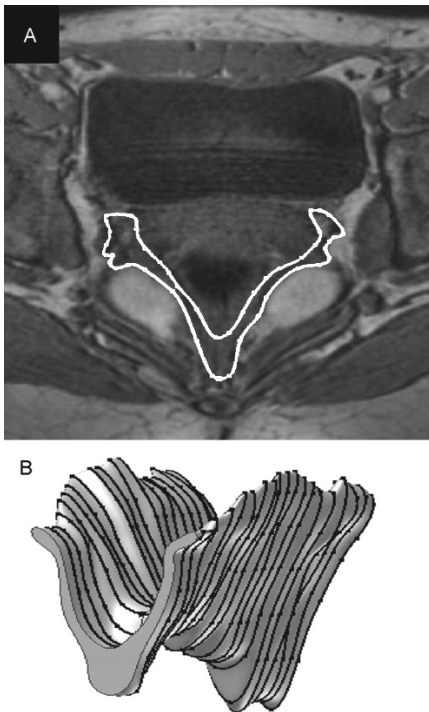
Construction of the pelvic floor model. (A) Levator ani muscle manually outlined from MRI image. (B) 3D computer model generated model from 20 MRI images. MRI, magnetic resonance imaging⁷³.
